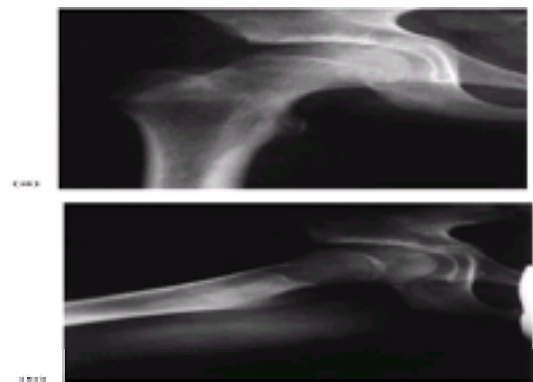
Radiographs of mild slipped capital femoral epiphysis.(a) Anteroposterior view; (b) frog lateral view.
